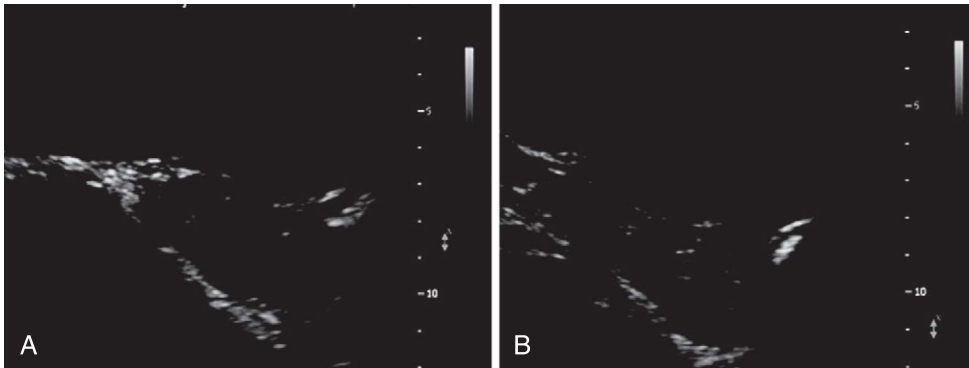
A and B, Ultrasound appearance of ovarian torsion in a prepubertal girl. (From Andreotti RF, Shadinger L, Fleischer A: The sonographic diagnosis of ovarian torsion: Pearls and pitfalls. *Ultrasound Clin* 2:155, 2007.)
